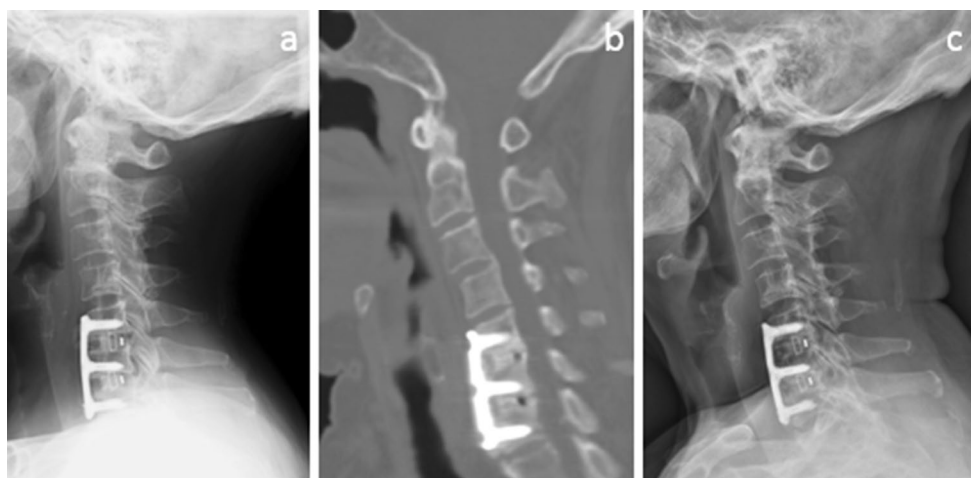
Serial follow-up for an 84-year-old female who received C5/6 and C6/7 ACDF with PEEK cages packed with β -tricalcium phosphate. a 12 months postoperative lateral radiograph; b sagittal-view CT scan showing fused at 12 months; c 24 months postoperative lateral radiograph
